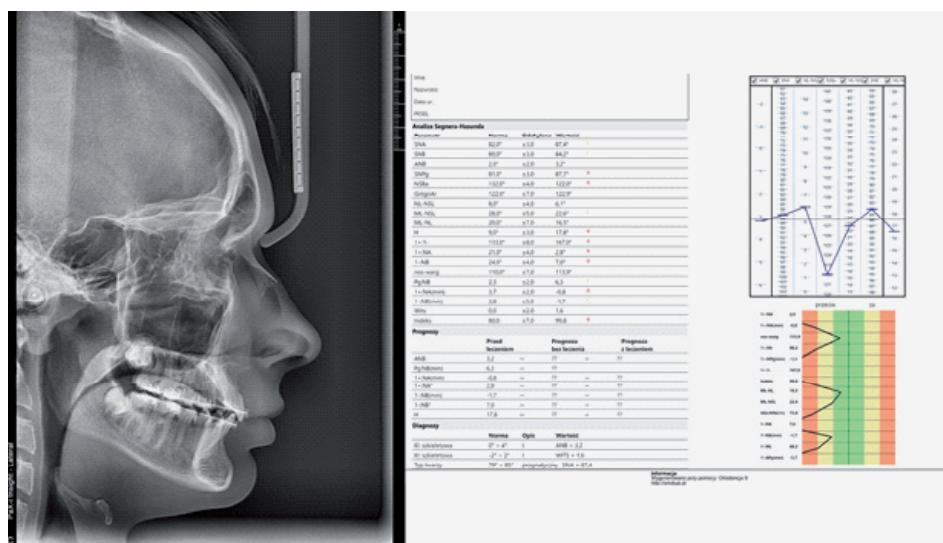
Cephalometric X-ray and Segner-Hasund analysis
